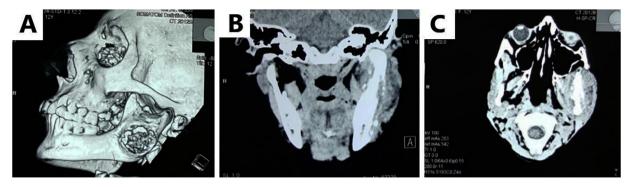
CT scan imaging. A) 3D reconstruction demonstrates the cortical osteolytic changes of the ramus. B) Coronal section shows the bicortical bone changes of the left ramus and the surrounding heterogeneous lesion of the related musculature. C) The extent of the lesion in axial view.
